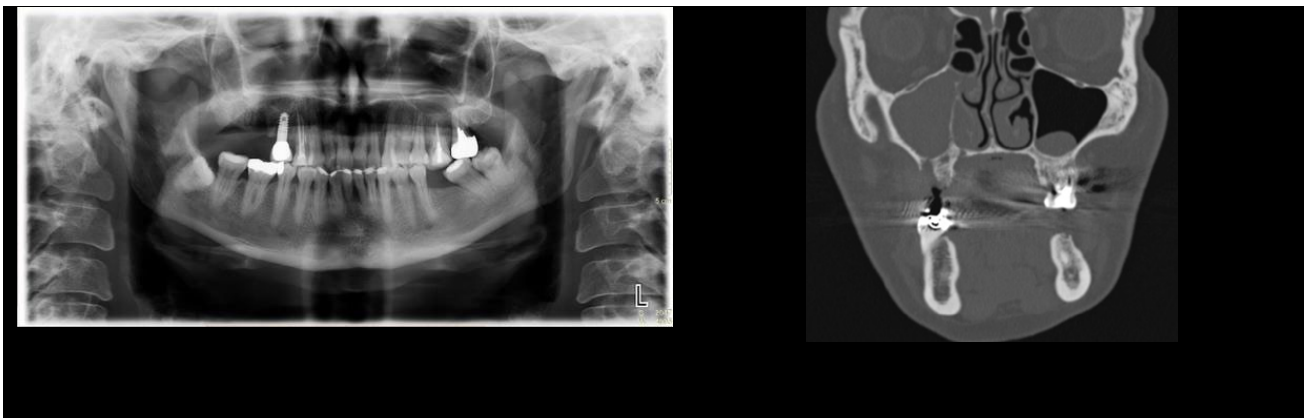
Left: OPT performed after an extraction procedure in the upper jaw shows no sign of MRONJ. Right: CT shows a clear imaging of MRONJ as well as the communication with the maxillary sinus fully occupied.
